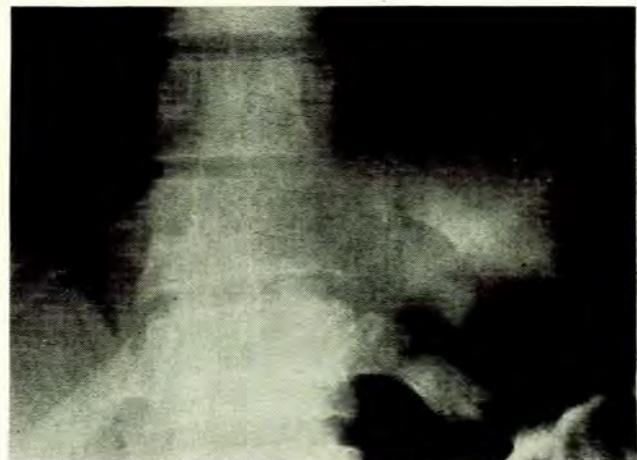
X-ray of the lower thoracic spine showing partial destruction of the body of the eleventh thoracic vertebra.
